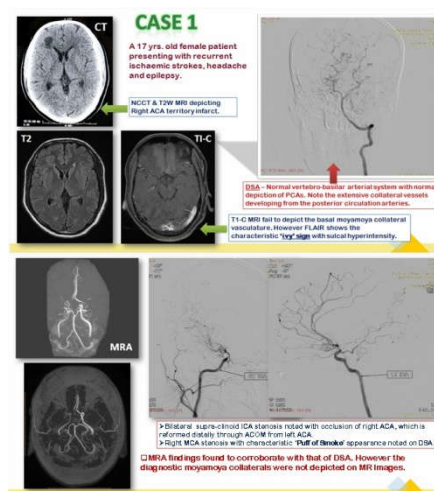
Case study showing NCCT, MRI, MRA and DSA findings in a 17 years old female diagnosed with Moyamoya disease
